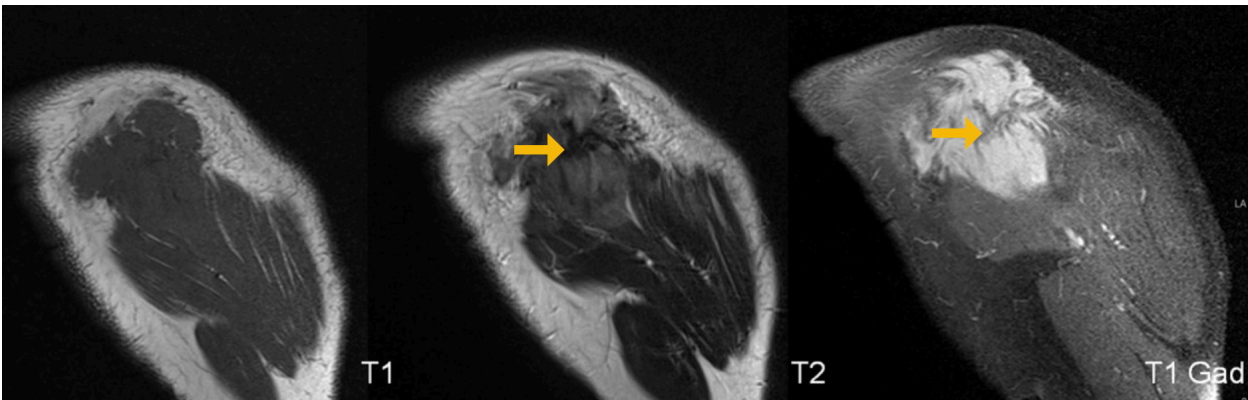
Deep fibromatosis of the left deltoid in a 52-year-old female. Coronal MR images showing a mass centered in the left deltoid muscle with isointense signal on T1-weighted images, faint hyperintense signal on T2-weighted images and avid contrast enhancement. Note the central T2-weighted hypointense and non-enhancing collagen bands (arrows).
